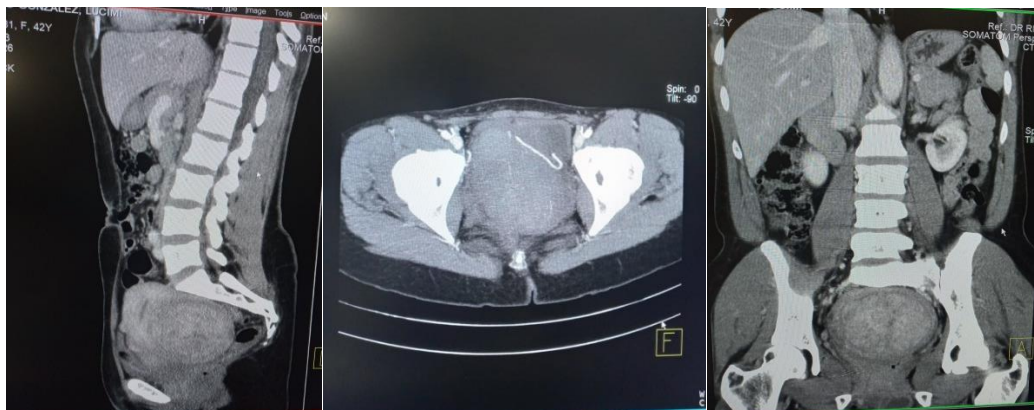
Abdominal CT scan showing a large posterior uterine tumor compressing the bladder and presenting vessels that appear to be neof ormations.
